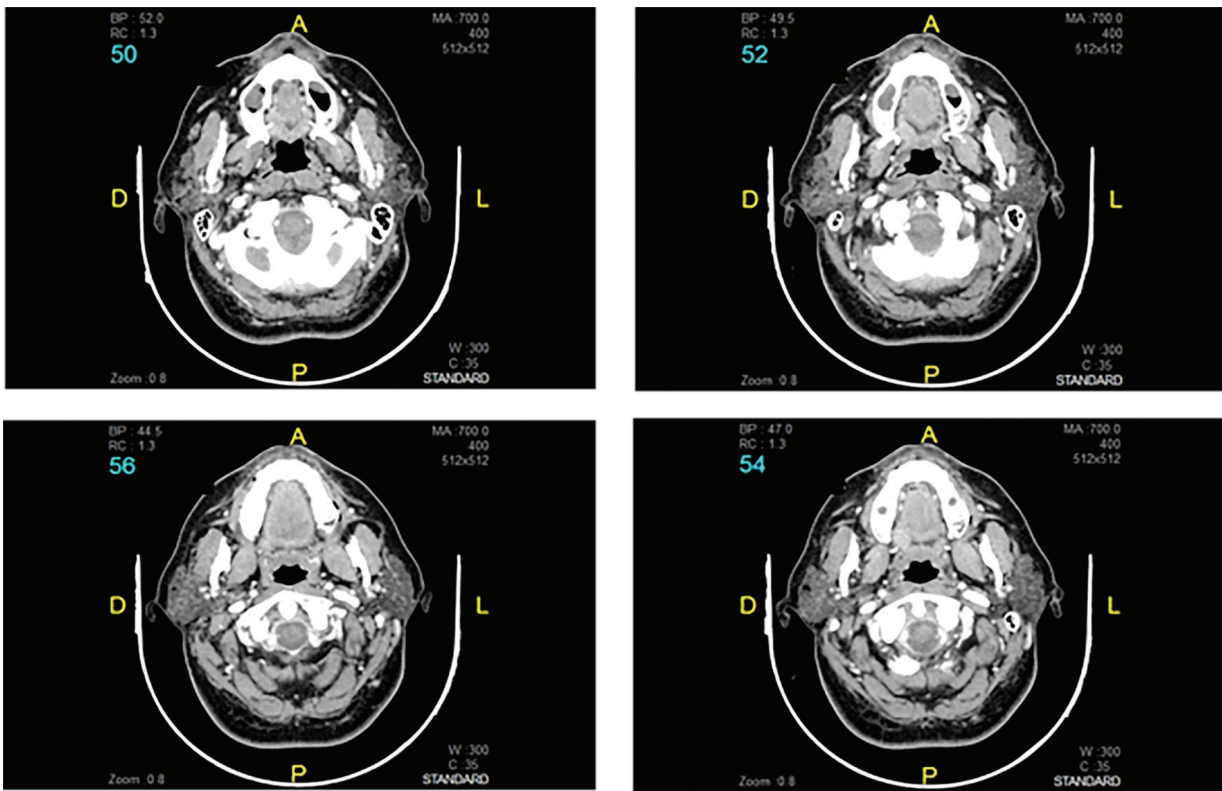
CT scan showing no underlying bony invasion.
